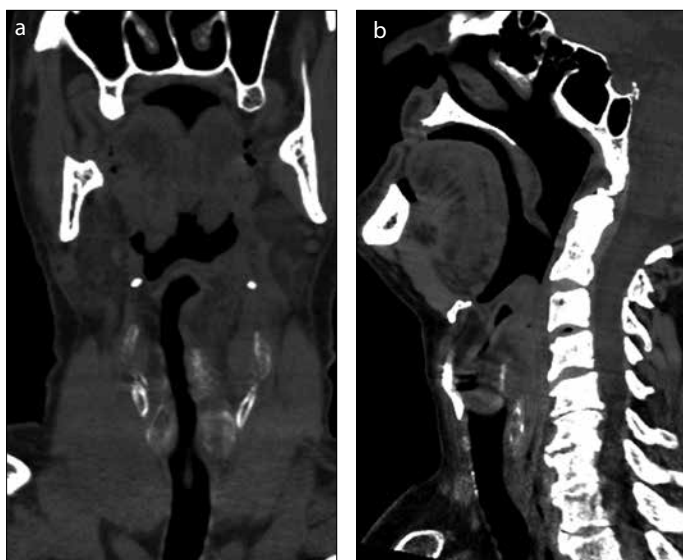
a) Coronal and b) sagittal CT reformation shows swelling and hematoma of laryngeal soft tissues that partially closed the left airway
